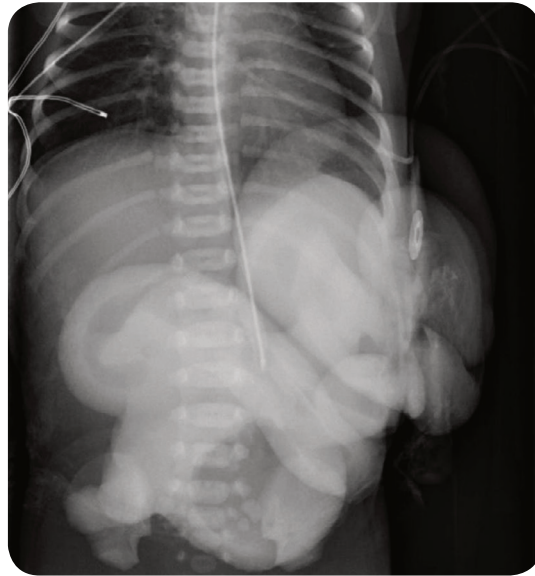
An abdominal X-ray of a newborn with gastroschisis. The abdominal contents are clearly visible outside the abdominal wall.
